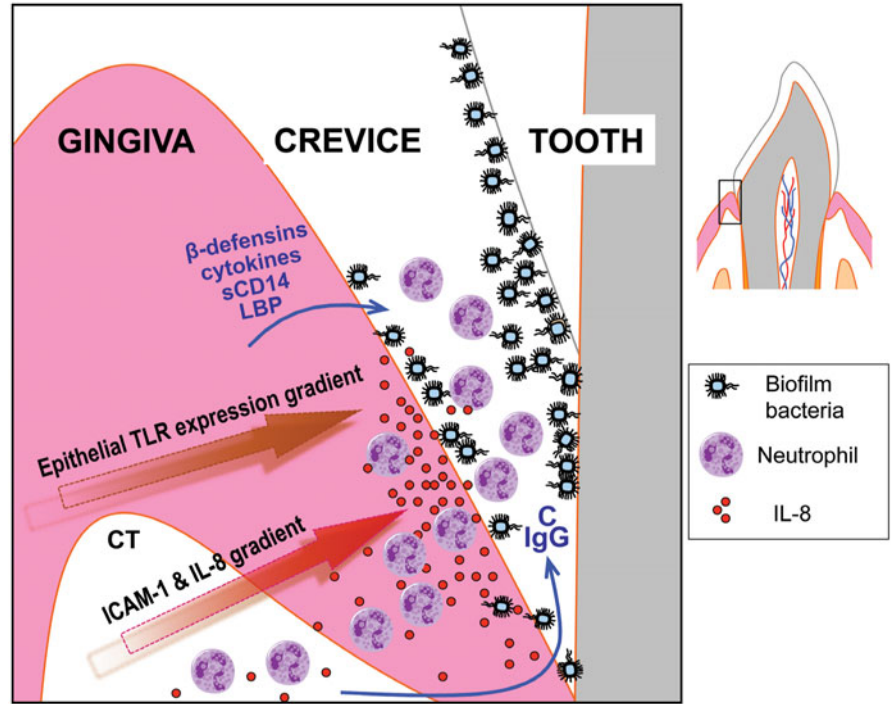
Important host immune factors in the gingival crevice. The presence of subgingival biofilm elicits host immune responses aiming to control the bacteria. Neutrophils are recruited from the vasculature to the gingival crevice following a pathway that is defined by a gradient of chemokines and cell adhesion molecules, such as IL-8 and intercellular adhesion molecule-1. The gradient becomes denser toward the upper epithelial cell layers which are closer to the bacterial challenge. Toll-like receptor expression in the gingival epithelia also becomes denser in the spinous epithelial layers compared to the basal layers, which are more remote from the biofilm. The induction of production of antimicrobial peptides (e.g., β -defensins) by gingival epithelial cells depends on the activation of Toll-like receptors by periodontal bacteria. Epithelial cells also express IL-8 and other cytokines, as well as soluble CD14 and lipopolysaccharide-binding protein, which potentially contribute to bacterial clearance. Neutrophils, as well as other leukocytes present in the junctional epithelium or the connective tissue, produce cytokines and antimicrobial molecules (e.g., α -defensins) which transit to the gingival crevice. The crevice also contains functional complement and IgG antibodies derived from the circulation or from local gingival production. C, complement; CT, connective tissue; ICAM-1, intercellular adhesion molecule-1; LBP, lipopolysaccharide-binding protein. doi:10.1128/9781555818906.ch10.f4
